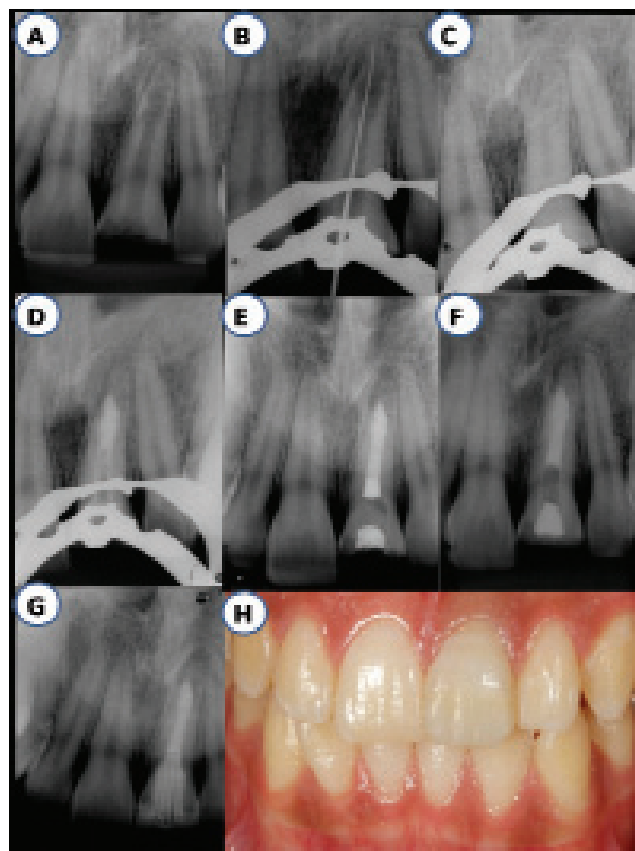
(A) Radiographic aspects of apical third root resorption observed in the tooth (21). (B) Crown-down technique performed. (C) Root canal filled with calcium hydroxide dressing. (D) MTA condensed into the apical resorption cavity after 14 days. (E) Canal filled using lateral condensation. (F) Six-month follow-up. (G, H) One-year follow-up: radiographic and clinical aspects.
